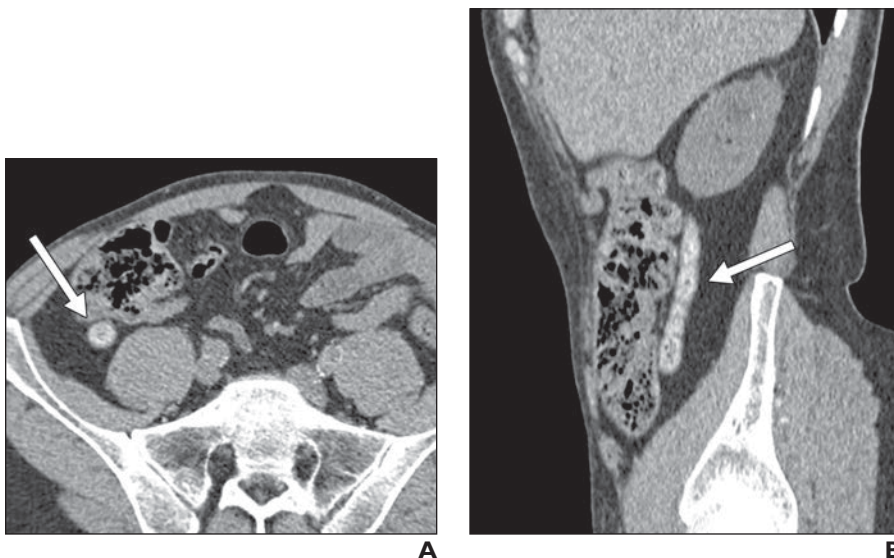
50-year-old man with cystic fibrosis and no abdominal pain. Transverse (A) and sagittal (B) unenhanced CT reformations show enlarged appendix (arrow) with hyperattenuating content.
